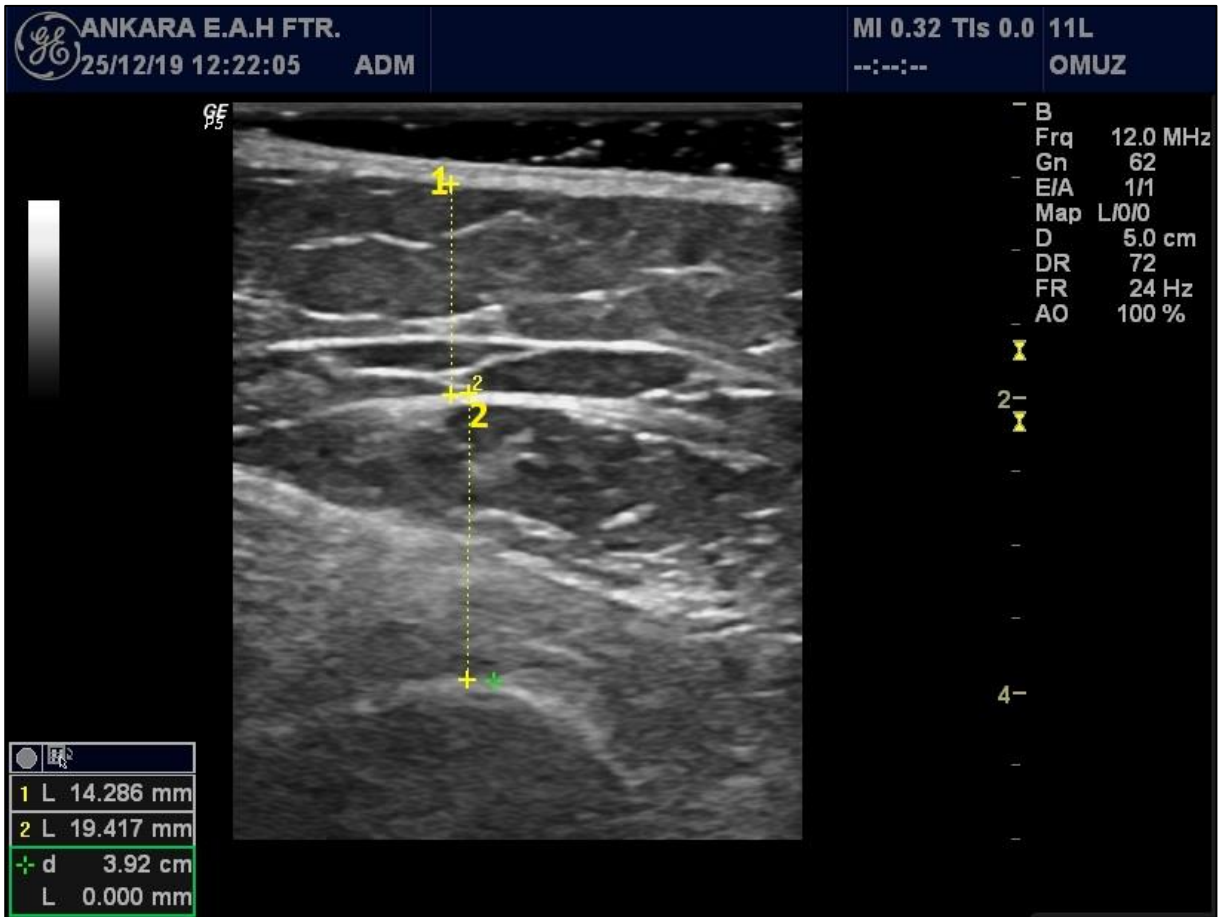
Ultrasonographic measurement of quadriceps femoris muscle thickness (2) /thigh subcutaneous fat thickness (1)
